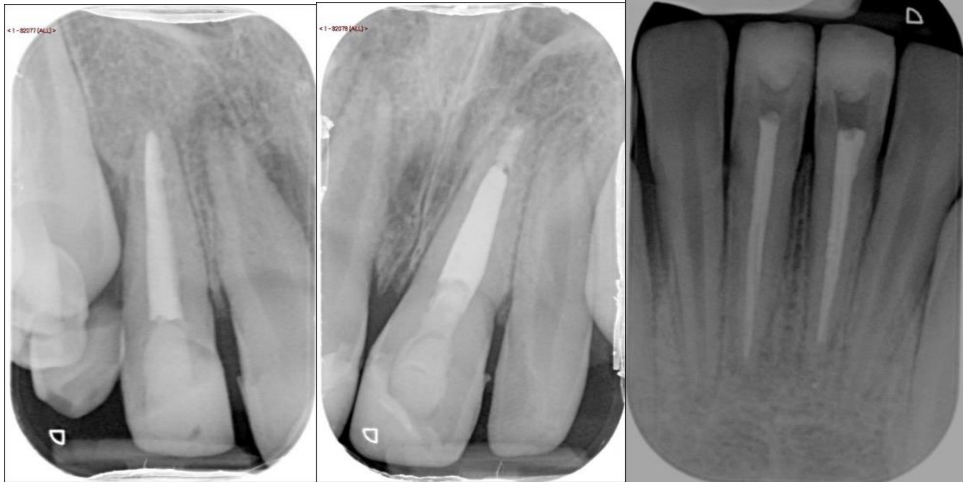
PA radiographs at one year, four months review
